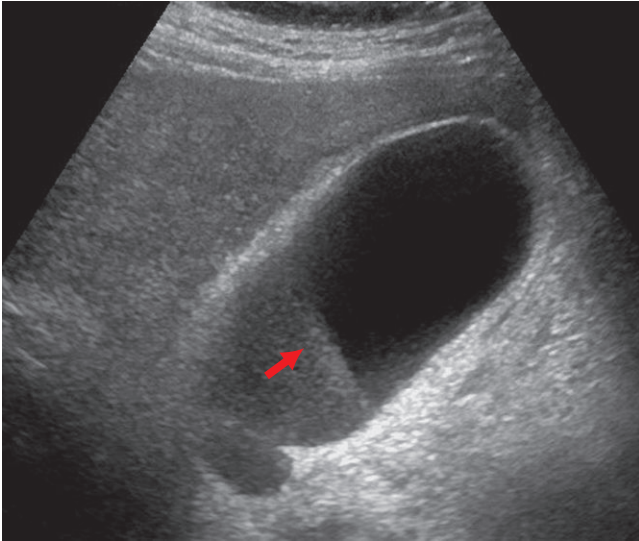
The sagittal sonographic image of the gallbladder shows a distended lumen, layering sludge (arrow), and a normal wall thickness.
